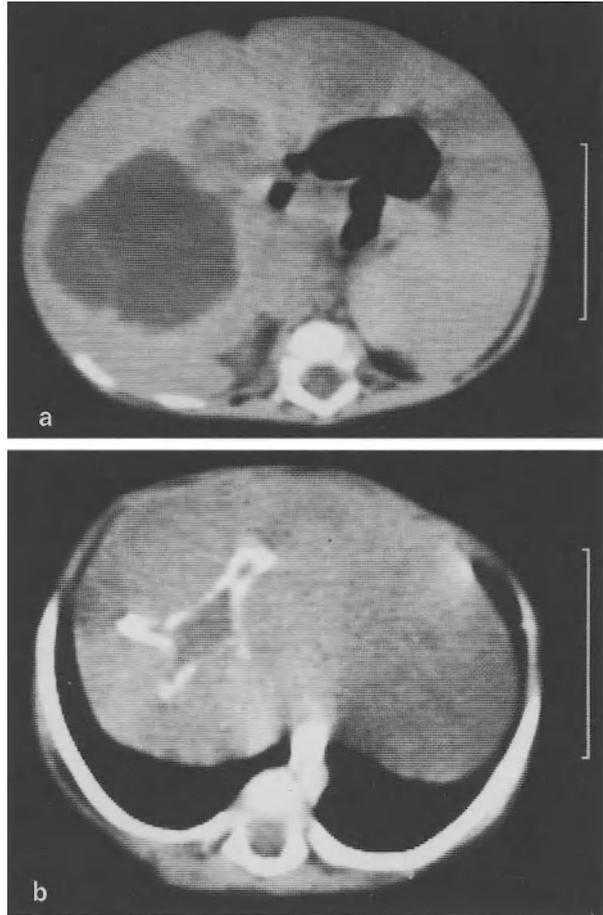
a Computed tomogram showing a large necrotic hepatoblastoma. b Repeat examination after embolism and injection of contrast medium now shows the lesion to be well defined and contrast medium outlines the capsule
